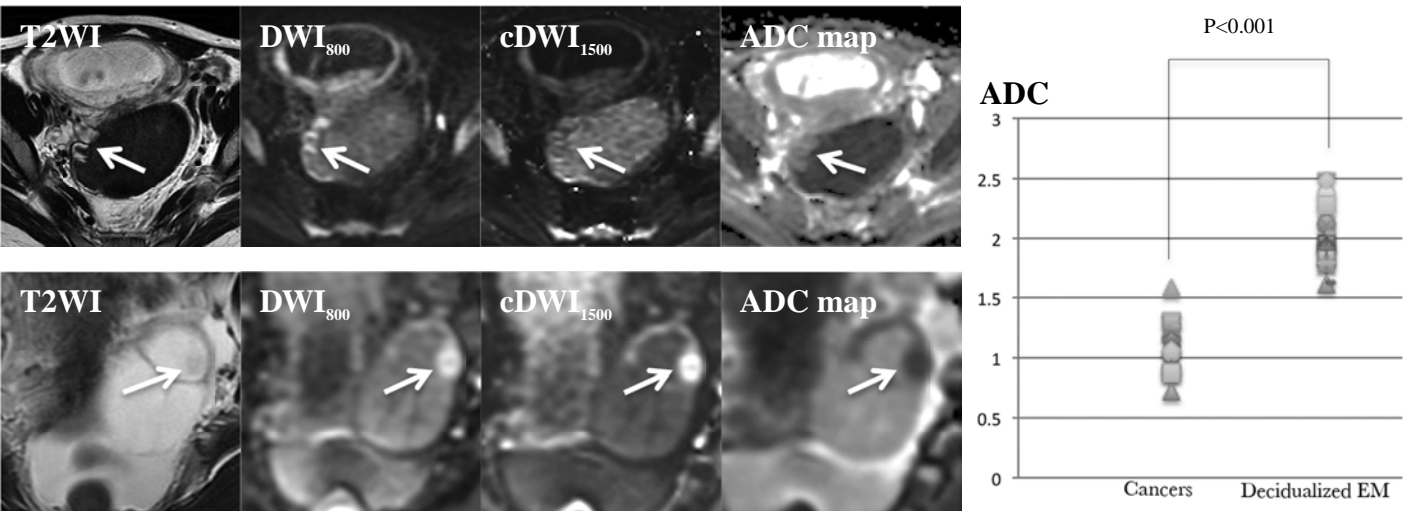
29-year-old pregnant woman with decidualized endometrioma. Small high intensity mural nodules on T2WI and DWI with relatively high ADC decrease the signal intensity on cDWI₁₅₀₀. Fig. 2: 40-year-old woman with ovarian cancer. High intensity mural nodule on T2WI and DWI with low ADC shows no signal decrease on cDWI₁₅₀₀. Fig. 3: The ADC values of decidualized endometriomas and ovarian cancers.
